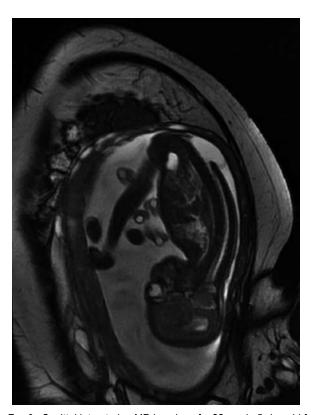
Sagittal intrauterine MR imaging of a 22-week, 5-day-old fetus demonstrating a neural tube defect inferior to L-3. There is an absence of the posterior elements in the lumbar area. A large dorsal MMC measuring  $3.7 \times 1.4$  cm with the neural placode in the sac is identified.
